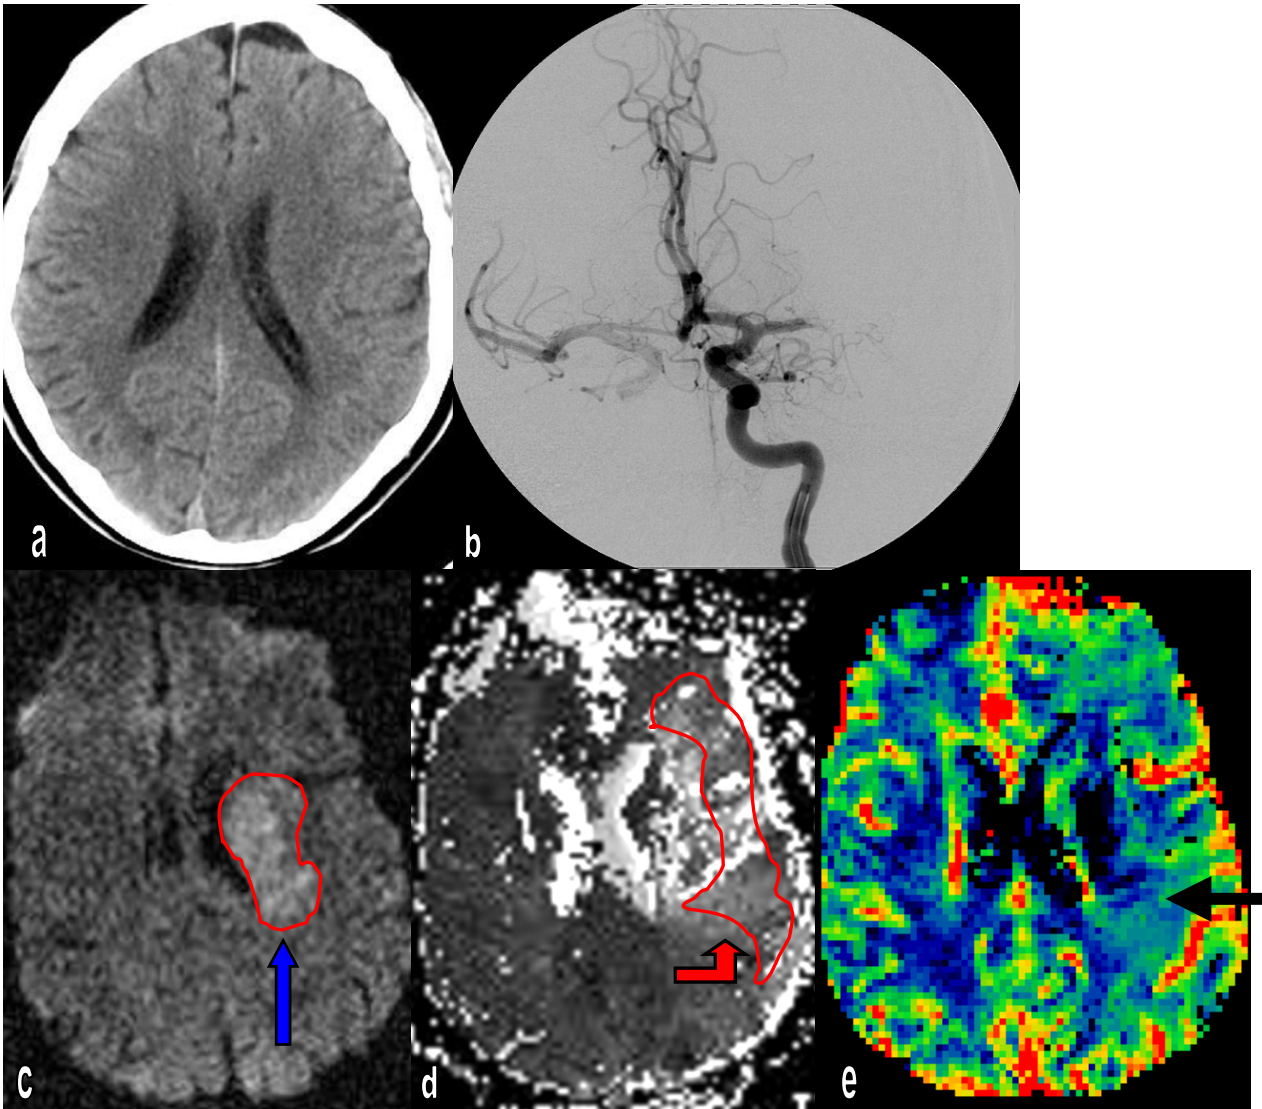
L. F. M/67. The patient could not speak and his right side could not move. The initial NIHSS was 12. CT (a) found a dubious hypodense on the lens. Both DWI and PWI (c and d) showed a hyperintense deficit on left MCA territory. DSA (b) showed occlusion was in the proximal M1 segment. A spontaneous reperfusion was established at the time of MRI within 2.5 hours after onset. After the systemic thrombolysis, a mechanical aspiration by means of Angiojet was successfully performed. His mRS outcome score was 4.
